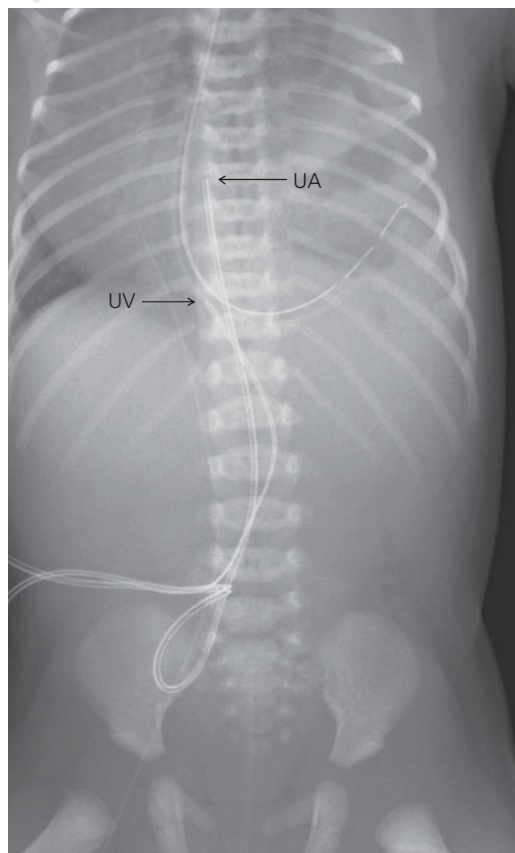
X-ray of high lying umbilical artery catheter (UA) and umbilical vein catheter (UV) in desired position.
